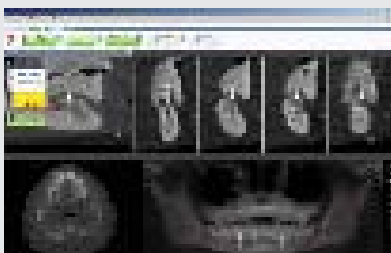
Mini implant planning on Iluma CT
